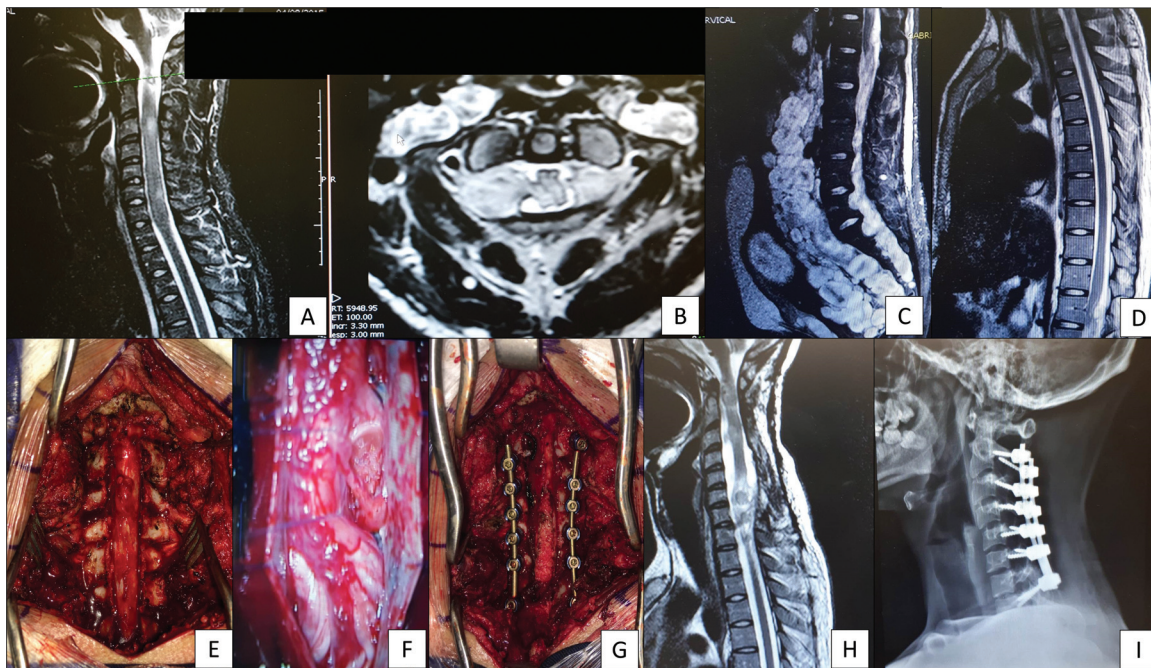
Sagittal (A) and axial (B) cervical T2-weighted sequence MRI scans of an 18-year-old patient with multiple kissing neurofibromas and severe tetraparesis. He underwent a C2–C7 laminectomy with duroplasty for enlargement of the spinal canal with microsurgical partial resection of the multiple neurofibromas guided by neurophysiological monitoring (F). C2–T1 posterior instrumented fusion was performed to avoid postlaminectomy deformity. Postoperative sagittal T2-weighted sequence MRI showing good spinal cord decompression (H); final plain cervical lateral radiograph (I). The neurofibroma at T12 was also submitted to surgery, and the patient had great improvement in his neurological deficits.
